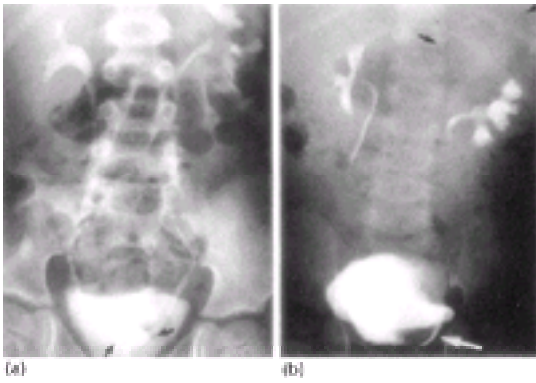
Radiographs of patients with ureterocele. (a) Seven-year-old boy with two small ureterocele (arrows). (b) Nine-month-old girl with large left ureterocele. Note displacement of adjacent lower pole downward and laterally by faintly visualized, hydronephrotic upper pole (arrows). Upper pole nephroureterectomy was performed at age 9 months. Reflux persisted to lower pole of left kidney. Therefore, the left lower pole ureter was reimplanted at age 3 years. At age 5 years 45 per cent of the patient's total renal function was generated by the left kidney.
